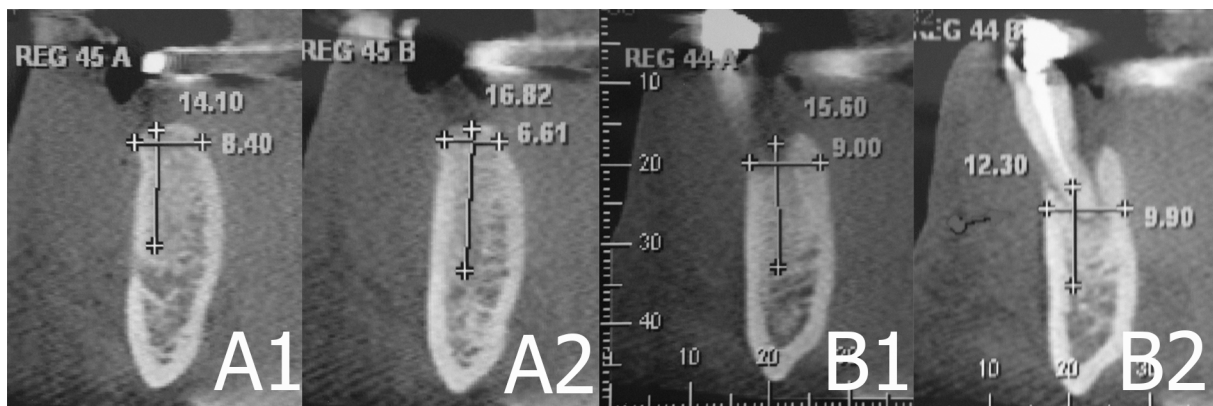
Remaining bone on tooth 44 (computed tomography - cross sections)
